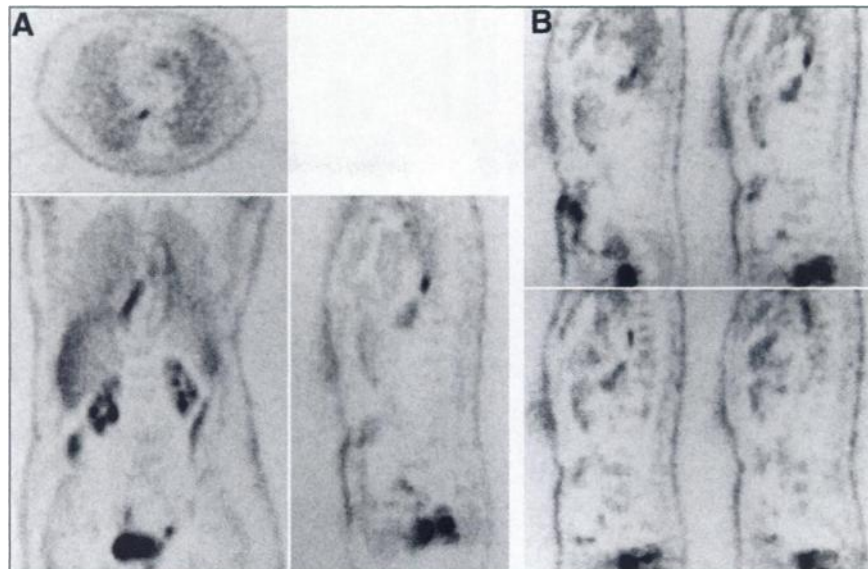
FDG PET scan without attenuation correction of 67-y-old man evaluated for metastatic melanoma. These transverse (top), coronal (bottom right) and sagittal (bottom left) images show physiological uptake in stomach.
